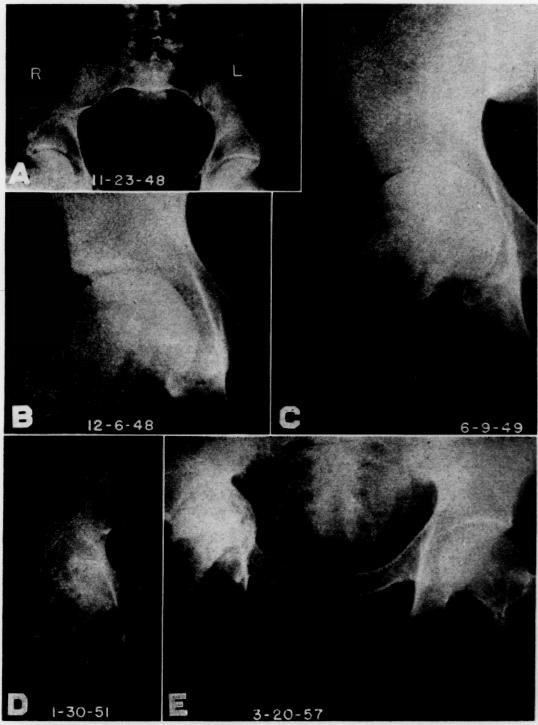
A, roentgenogram of pelvis (November 23, 1948) reveals normal hip joints bilaterally. B, roentgenogram of right hip (December 6, 1948) shows narrowing of the joint space and loss of sharp margination of the superomedial outline of the acetabulum. C, roentgenogram of right hip (June 9, 1949) demonstrates further progression with drifting of the femoral head medially. D, roentgenogram of right hip (January 30, 1951) reveals sclerosis and eburnation of acetabular margin with beginning protrusion of femoral head. E, roentgenogram of pelvis (March 20, 1957) shows further deepening of the acetabulum with superior and medial displacement of the femoral head; this now is a well developed protrusio acetabuli.
